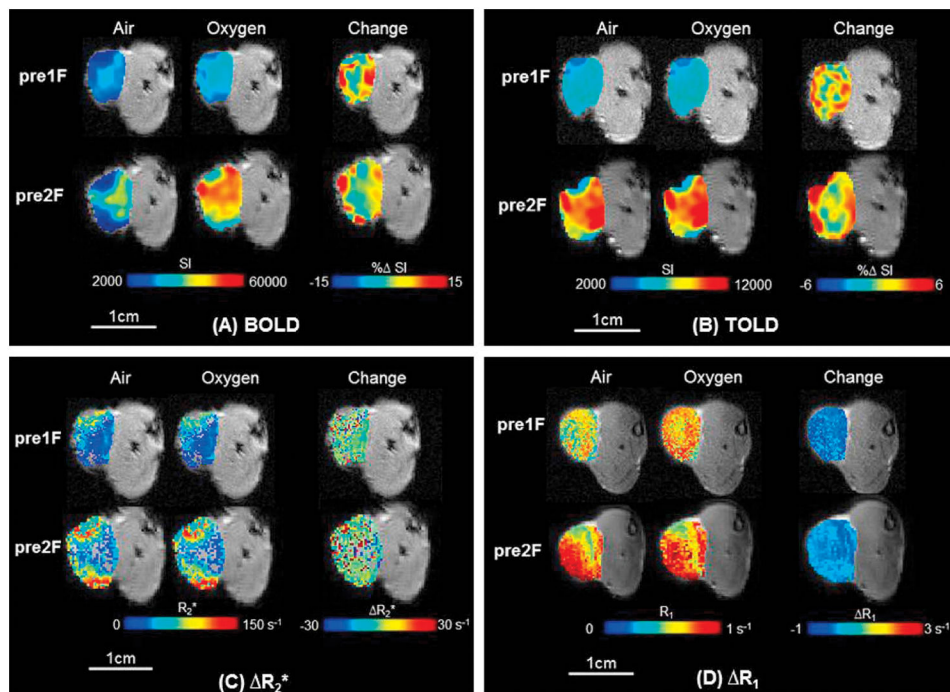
Oxygen-Enhanced MRI
